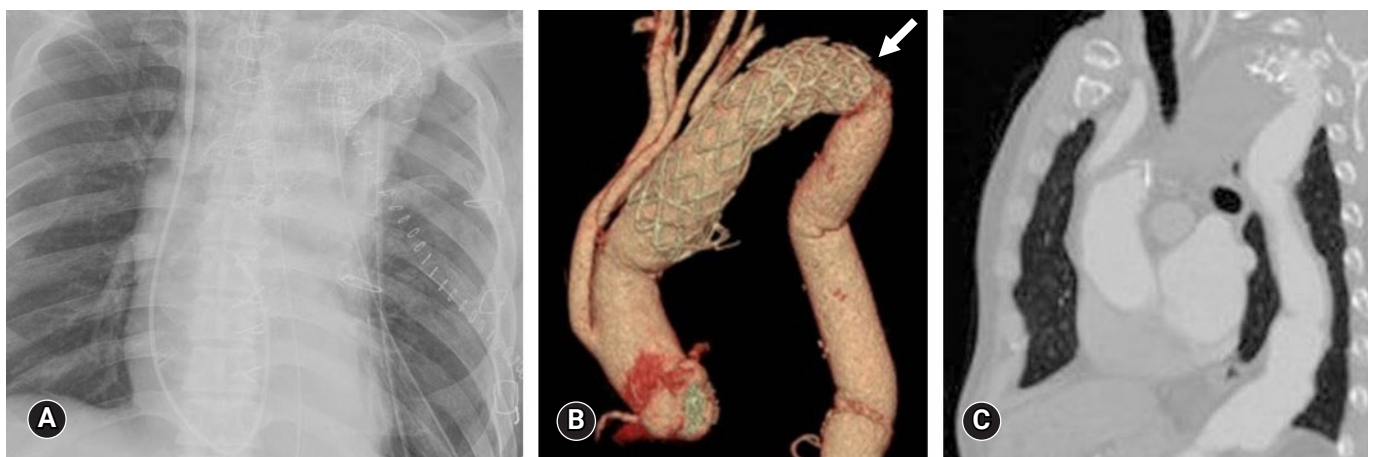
Postoperative chest radiograph and computed tomography (CT) findings of case 1. (A) Postoperative chest radiograph indicates a well-functioning Hemashield graft. (B) Postoperative chest CT indicates the absence of endoleaks (arrow). (C) Postoperative chest CT confirms the absence of a lung lesion.
